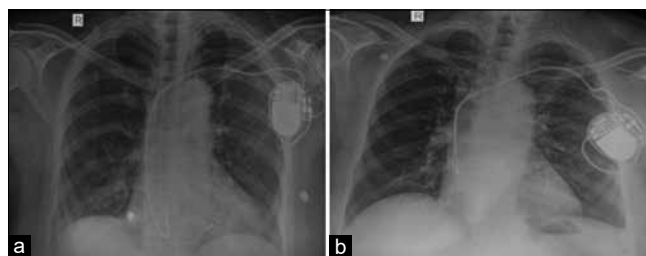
(a) Post left bundle branch (LBB) pacing Chest X-ray (Case 1), (b) Post LBB pacing Chest X-ray (Case 2)
